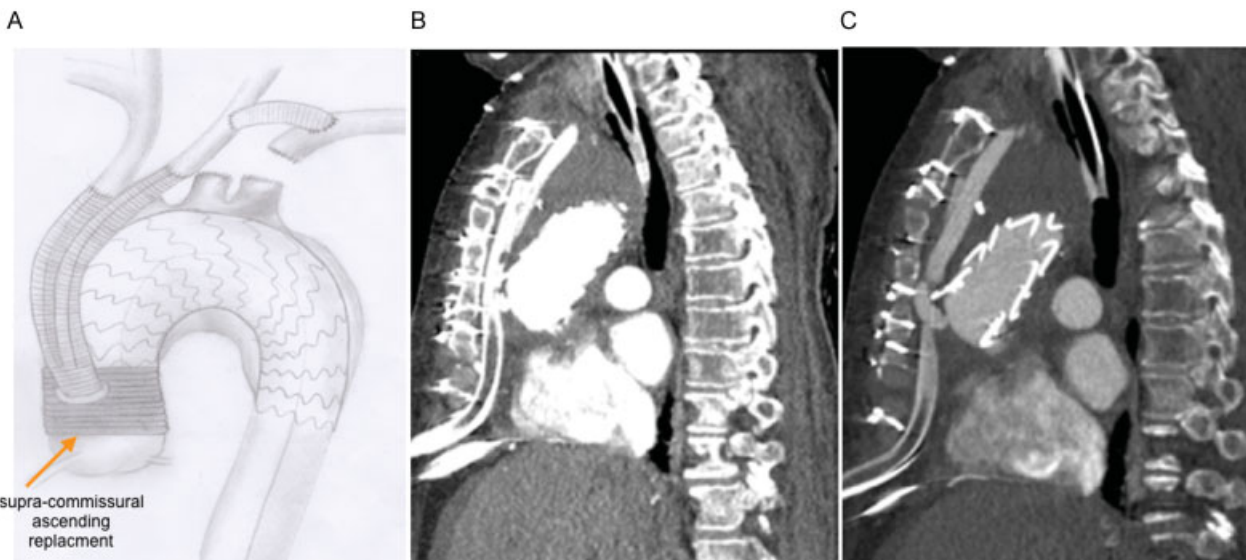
Redo surgery with replacement of the supra-commissural ascending aorta with a Dacron prosthesis, which was anastomosed to the stent graft excluding the rigid metal struts. Antegrade cerebral perfusion via the Y-graft. Reanastomosis of the Y-graft to the aortic prosthesis in end-to-side technique (A). Control computed tomography (CT) scan after 5 days (B) and 6 months (C).
